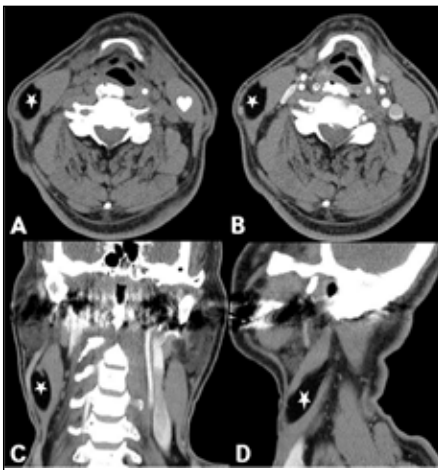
CT scans revealed a lobulated, fusiform, well-defined and non-enhancing 3.2×2.1×7.5 cm-sized mass (asterisk) with homogeneous adipose tissue signal density in the right sternocleidomastoid muscle. A: non-enhanced axial, B: enhanced axial, C: enhanced coronal, D: enhanced sagittal. Heart shape: normal left SCM)
